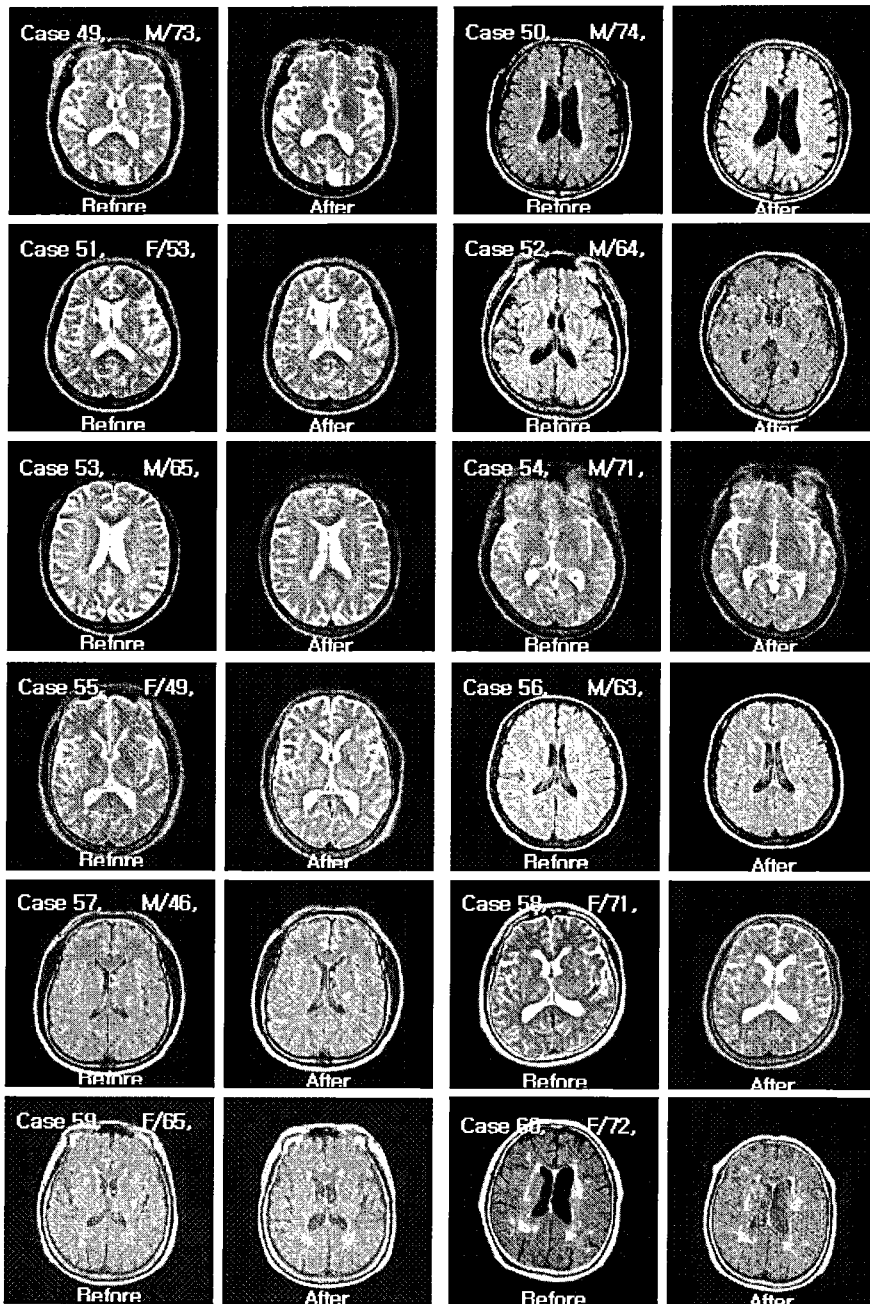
Brain MRI before and after 1 year of *Chunghyul-dan* medication in Cases 49 to 60
